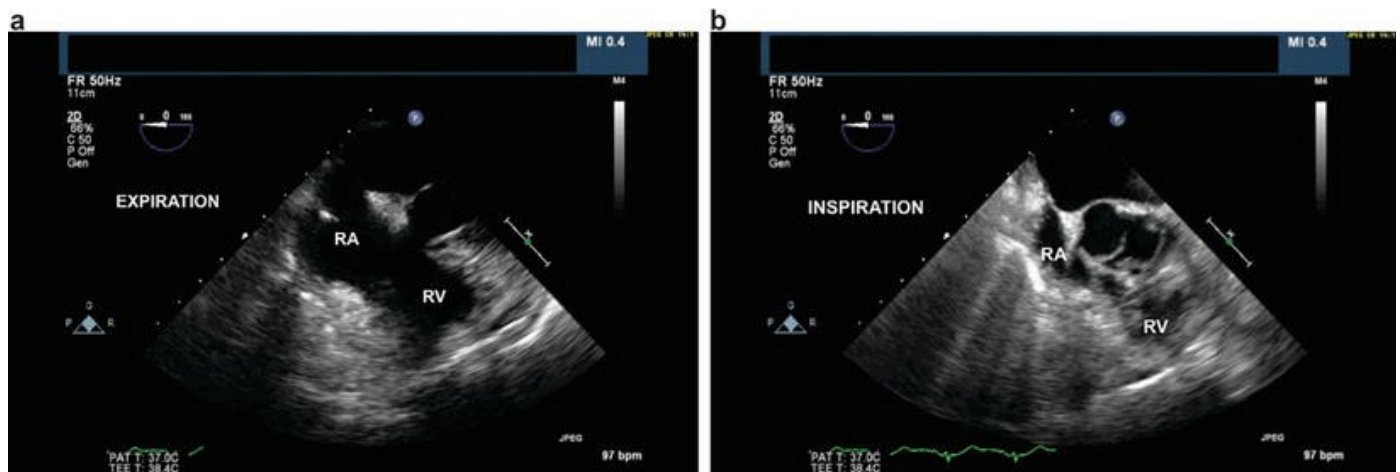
(a) Cardiac tamponade in lung transplant recipient with oversized allografts (during *expiratory phase* of the ventilatory cycle). Transesophageal echocardiogram (TEE) image obtained at mid-esophageal level depicting the right atrium (RA) and right ventricle (RV) cavities. The image demonstrates the RA and RV normally open during diastole. This patient was intubated and mechanically ventilated. TEE was performed in order to evaluate the possible etiology of hemodynamic instability in the immediate postoperative period after bilateral lung transplantation. (b) Cardiac tamponade in lung transplant recipient with oversized allografts (during *inspiratory phase* of the ventilatory cycle). Transesophageal echocardiogram (TEE) image obtained at mid-esophageal level depicting the right atrium (RA) and right ventricle (RV) cavities. The image demonstrates the RA and RV are completely collapsed by extrinsic compression during diastole. TEE examination confirmed diagnosis of cardiac tamponade caused by increased intrathoracic pressure in the setting of positive pressure ventilation and oversized allografts
